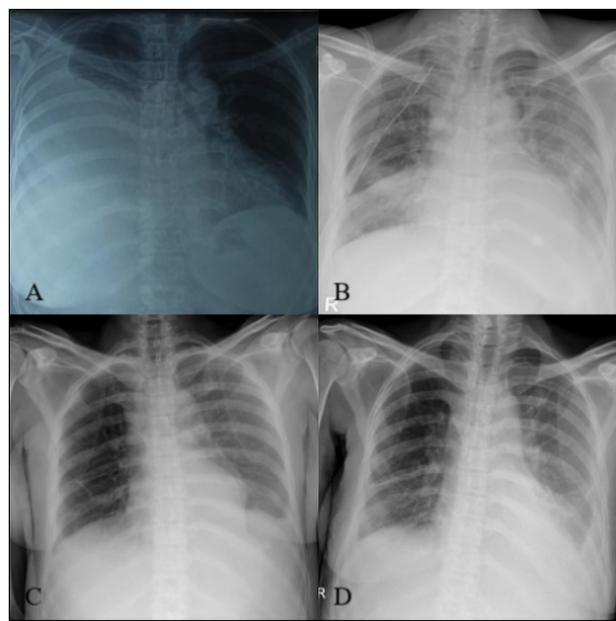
Sequential chest X-ray of the patient. A) At first hospitalization (April 2022), effusion in the right hemithorax. B) In May 2022, the patient had pneumonia and bilateral effusion. The patient had a chest tube installed, and the X-ray showed the chest tube attached with the tip pointing to the cranial projection at the 3rd right posterior intercostal. C) In June 2022, the second hospitalization showed reduced bilateral pleural effusion and fibrosis in the lower zone of the right lung, suspected to be part of the aging process. D) In August 2022, when the third hospitalization showed bilateral effusion with left-sided domination, metastatic type effusion was suspected, and an osteoblastic lesion of the right scapula was found, with metastatic bone disease suspected.
